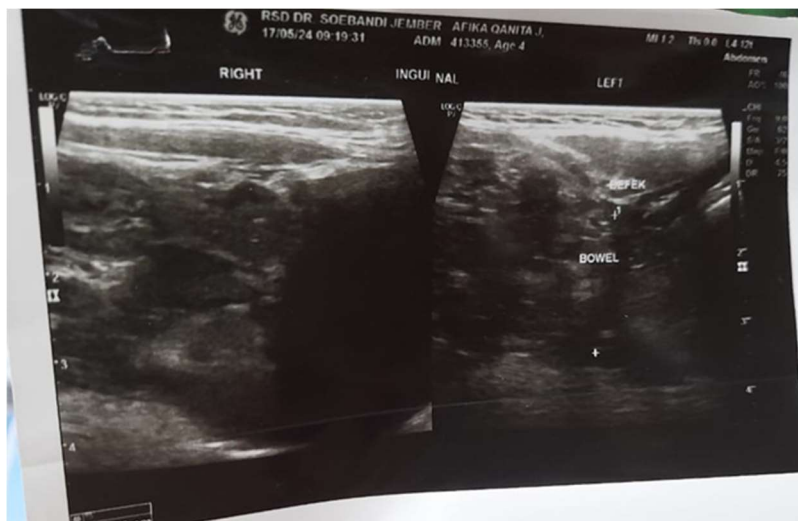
Pre-operative inguinal ultrasonography. Preoperative photo of a lump on the left labia majora.
